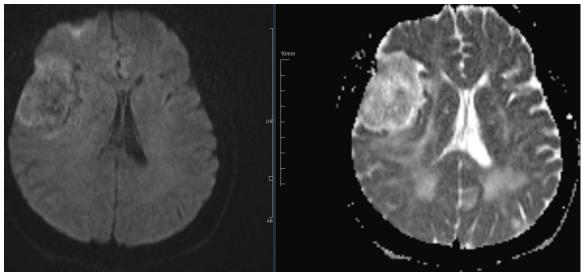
Diffusion MRI: A hemorrhagic lesion approximately 5x4 cm in size with heterogeneous contrast enhancement was detected in the right frontotemporal region. The absence of significant vasogenic edema in the surrounding parenchyma prompted a recommendation for further evaluation for hemorrhagic infarct versus mass.
